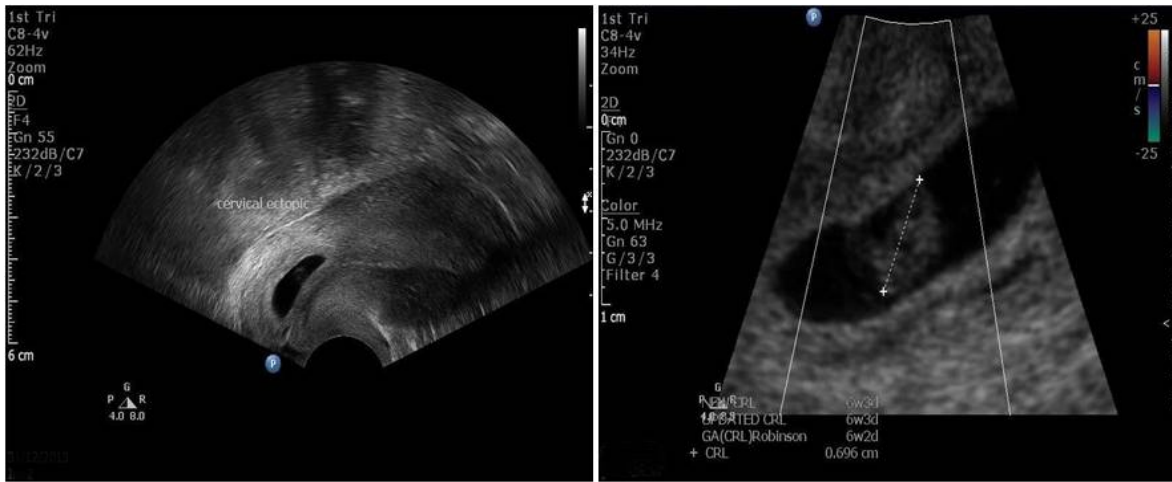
The trans-vaginal ultrasound scan picture on admission showing an empty uterine cavity and a regular sac in the cervix with fetal pole of CRL 0.69 cm equivalent to 6 weeks and 2 days
